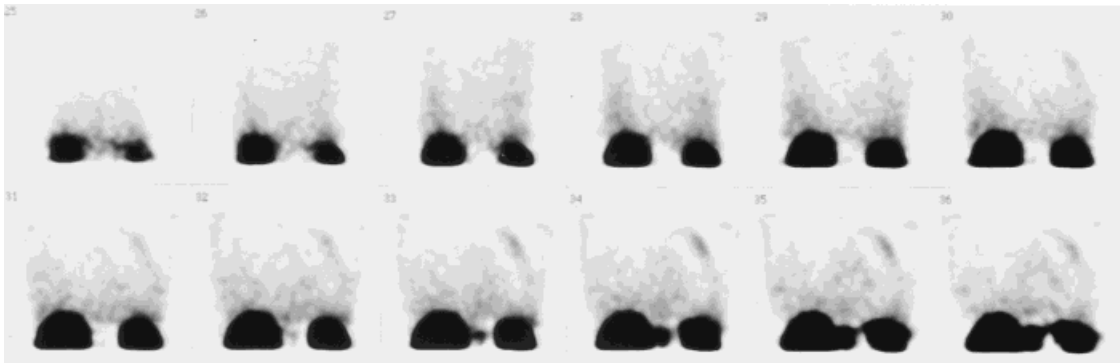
Single photon emission computed tomography demonstrated two areas of faintly increased uptake in the left lung.
